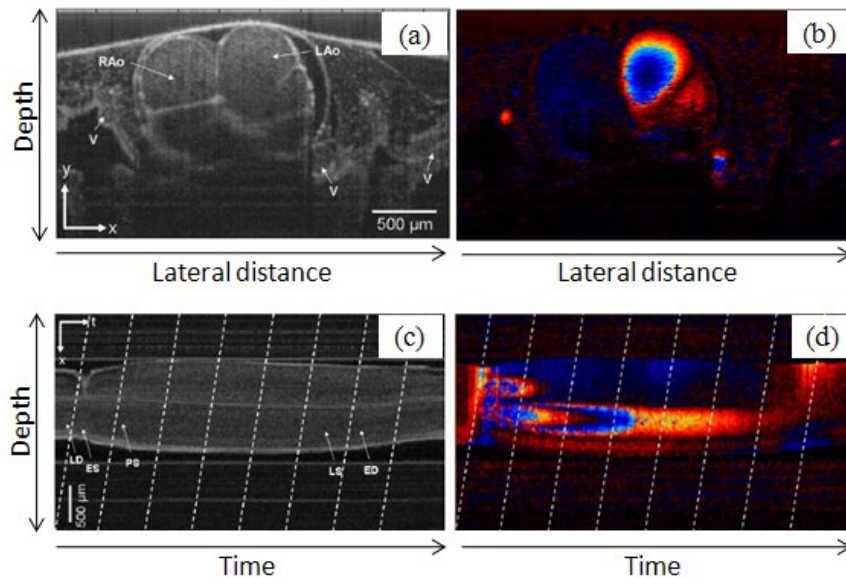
Examples of (a) B-Mode intensity map, (b) B-Mode Doppler map, (c) M-Mode intensity map, and M-Mode Doppler map (Mariampillai et al. 2007).
